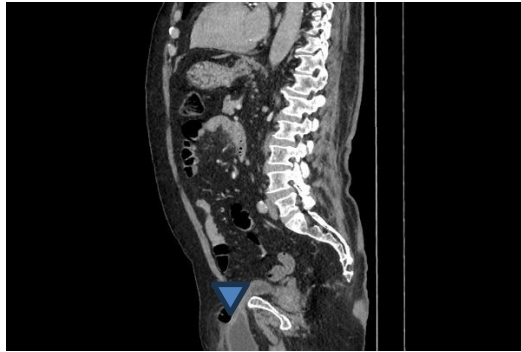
Sagittal reformat of the CT scan shows herniated bladder (arrow head) as hyperdense tissue in the anterior abdominal wall suggesting IBH.
